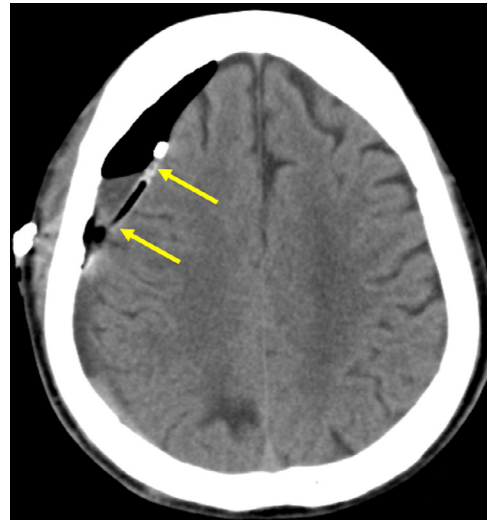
Noncontrast axial computed tomography scan taken on the day following burr-hole irrigation displays satisfactory removal of the subdural hematoma. Arrows: subdurally placed drain during surgery.
